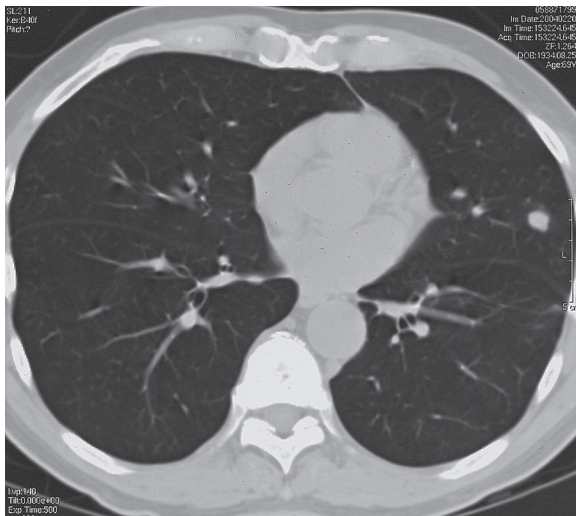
■ Computed tomography scan demonstrating a granuloma in the lingula caused by coccidioidomycosis.
